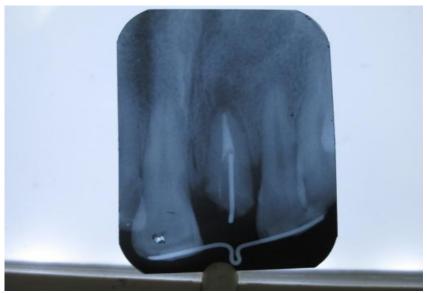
Radiographic photograph of #21 showing simple appliance for rapid orthodontic extrusion
